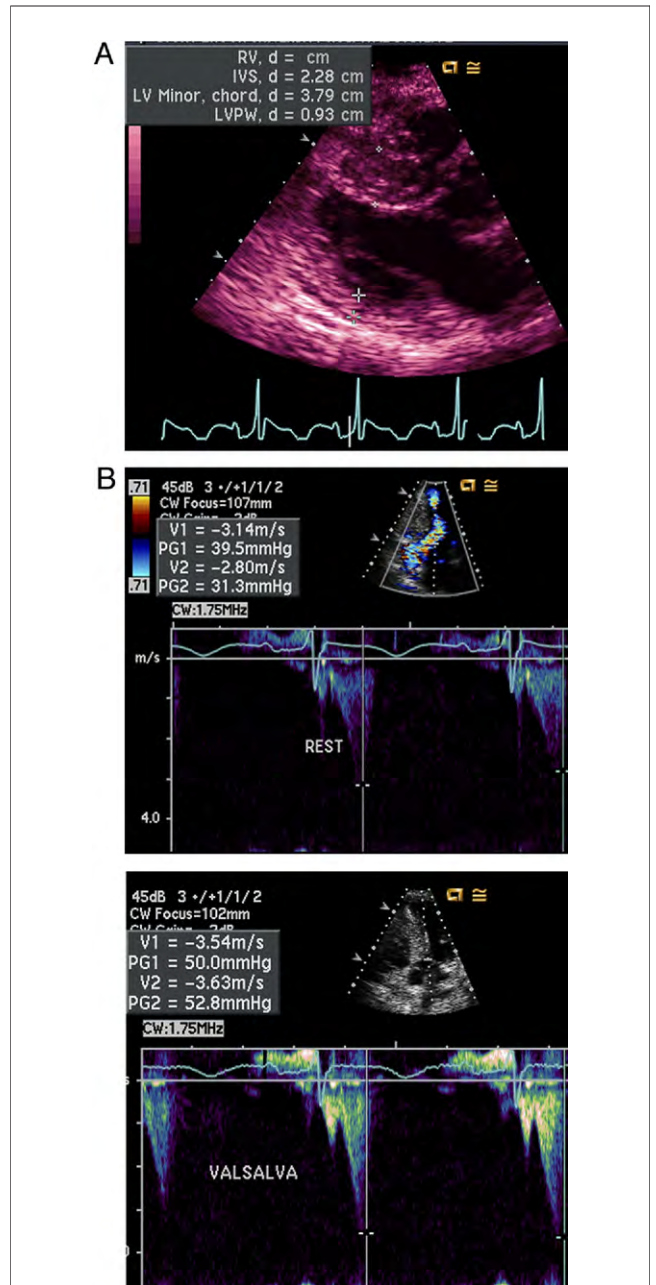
2-Dimensional Transthoracic Echocardiography in HCM
